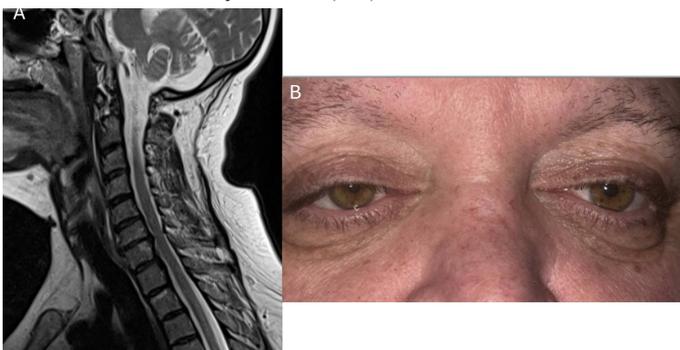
Case 2, A) MRI T2 sagittal image showing disc herniation and cord compression at C6-7, B) mild ptosis with miosis in right eye
